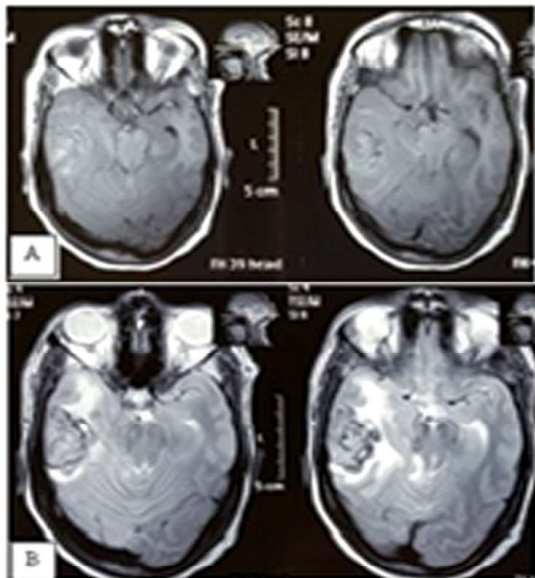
(A) MRI T1 image showing a hyper to hypointense heterogenous mass lesion in right temporal lobe with mass effect, the same lesion is hypo to hyperintense on T2 images (B) with flow voids.
